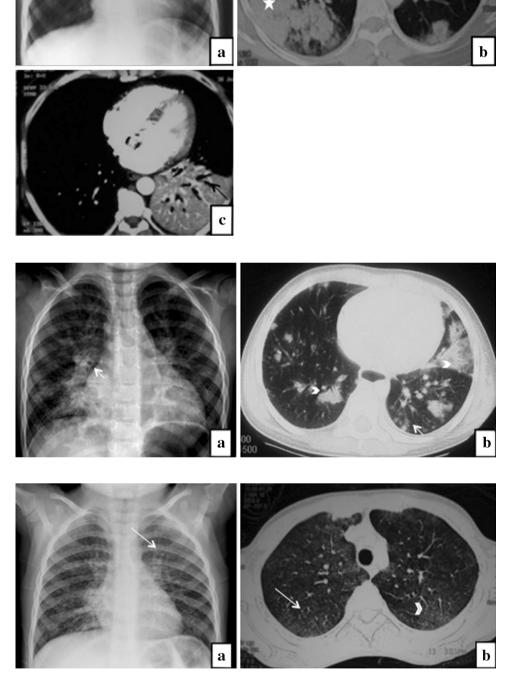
Nodular pattern of pneumonia in a case of miliary TB. a Chest radiograph shows the presence of bilateral nodular opacities. b Tiny random nodules(<5 mm) are seen in right lung on chest CT
